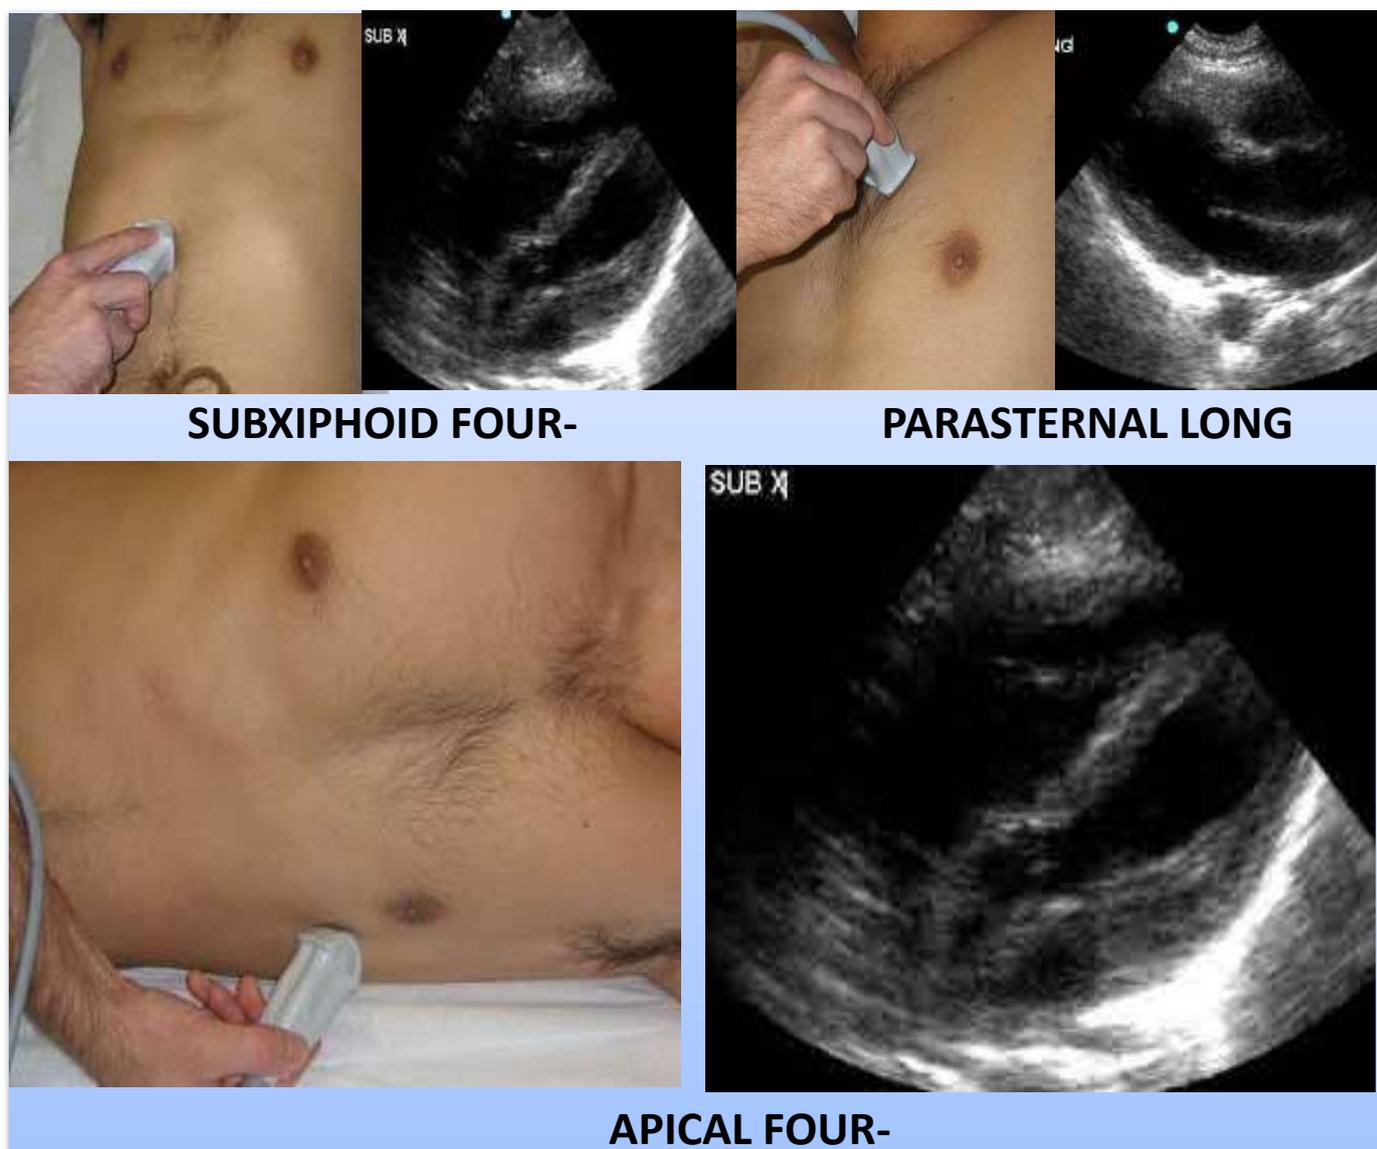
Cardiac Ultrasound views
